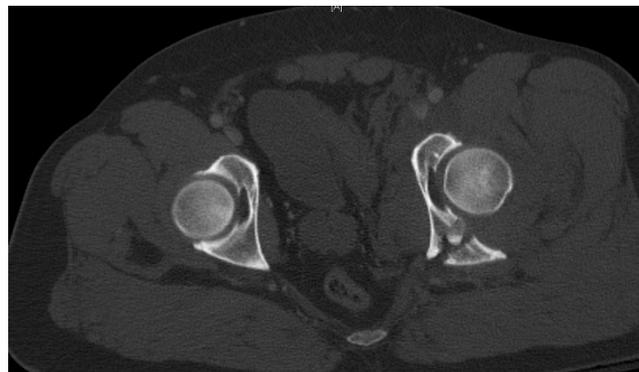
Bony windows of axial CT scan. (B) A comminuted posterior wall fracture is seen.
